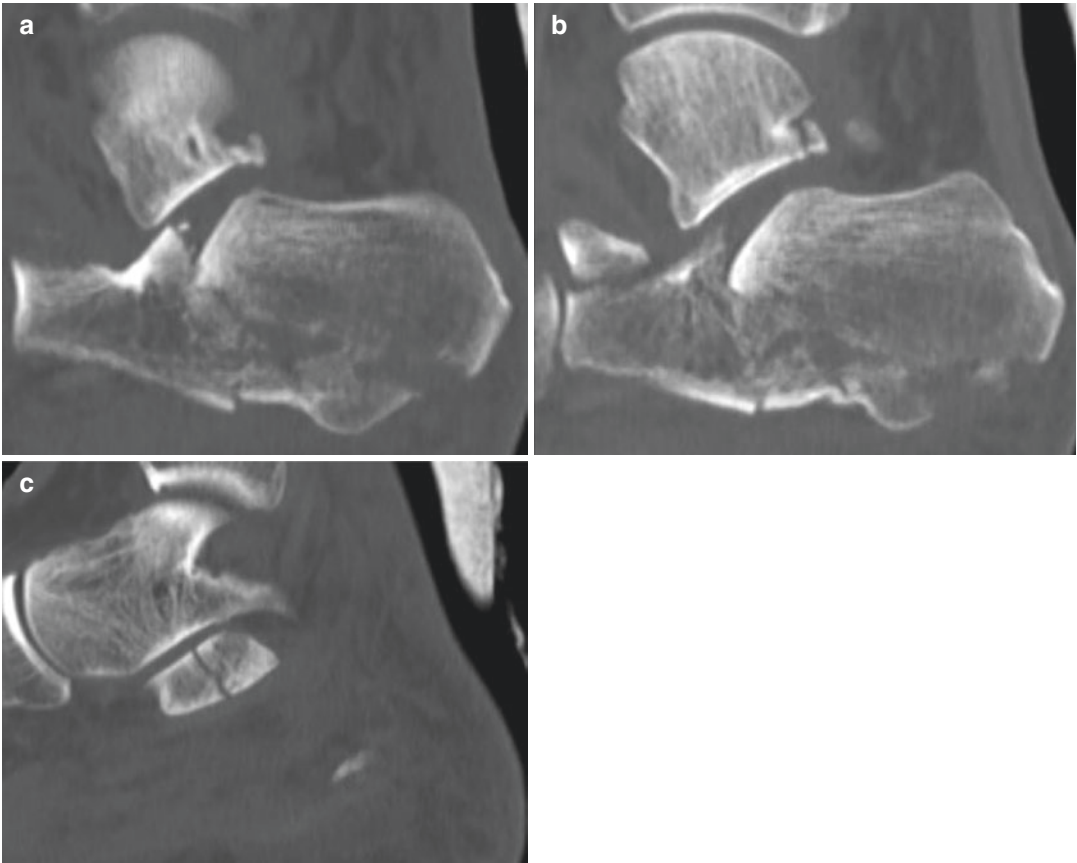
Sagittal CT images
